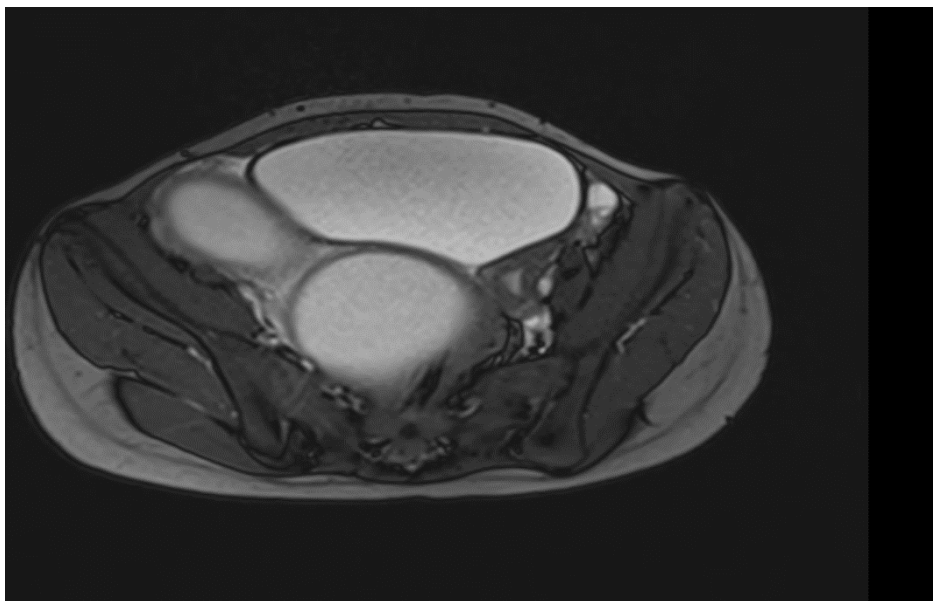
Axial pelvic MRI demonstrating uterus didelphys with marked distension of the right hemivagina and right hemiuterus secondary to an obstructed hemivagina.
